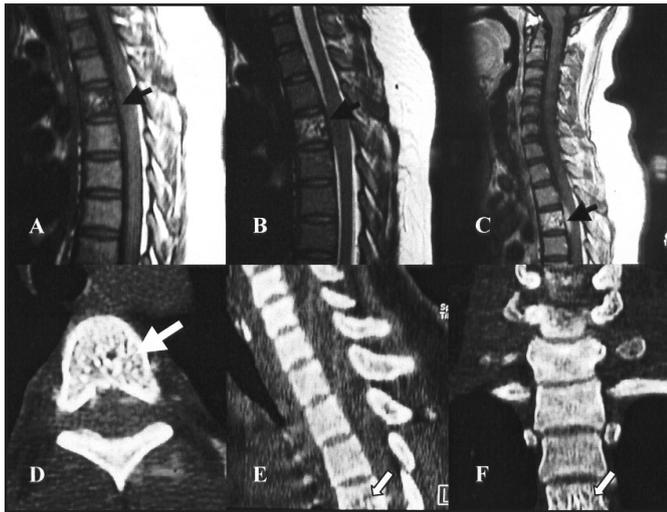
Sagittal MRI (A) T1WI and (B) T2WI showing isointense extradural lesion arises from T3 vertebra (white arrow). The lesion enhance intensely with gadolinium administration (C). Spinal reconstructed CT scan revealed typical 'polka-dot' pattern (white arrow) of T3 vertebra body on axial (D), and 'Corduroy' or 'jailhouse striation' appearance on sagittal (E) and coronal (F) plane (black arrow).
